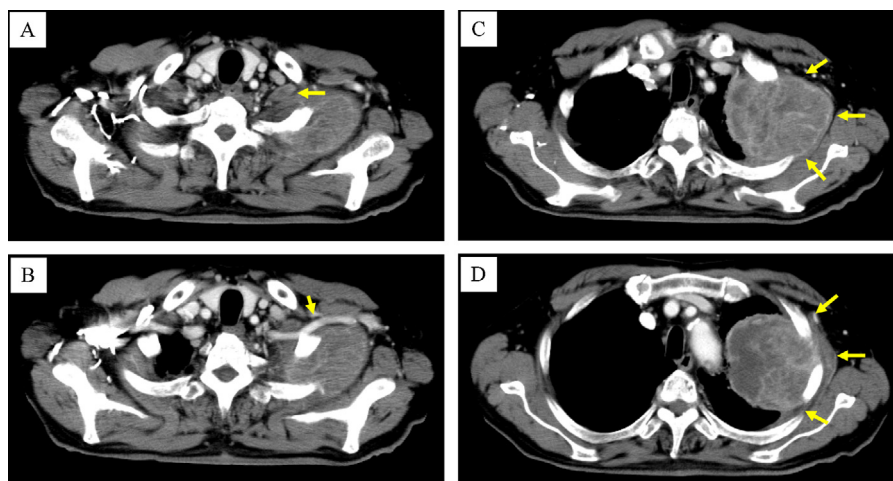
Computed tomography of the chest showing the localization of this tumor. This tumor located in the left apex thoracic inlet. Subclavian lymph node was swelling (A). This tumor touched subclavian artery (B). This tumor involved 1st, 2nd, 3rd ribs (C, D).
